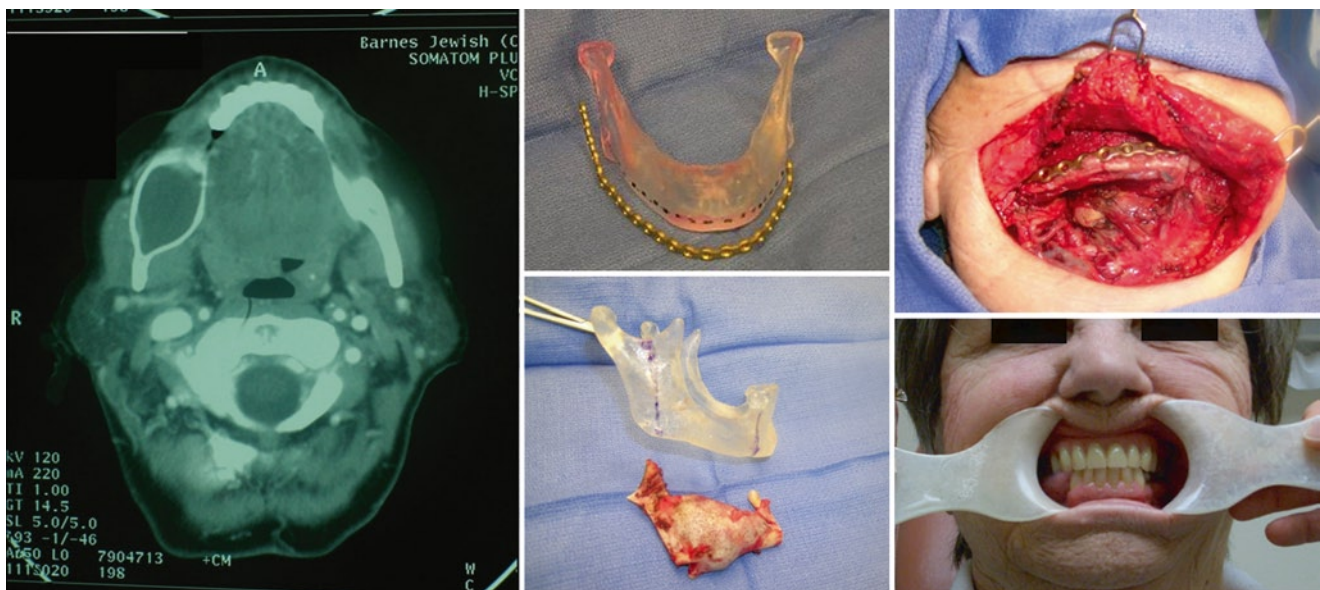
Medical models for reconstruction. Advances in three-dimensional imaging and technologies allow precise models to be created for preoperative reconstruction planning. An axial CT image reveals an expansile cystic lesion (*left image*). Surgical planning to remove this dentigerous cyst includes a generated mandibular model for
